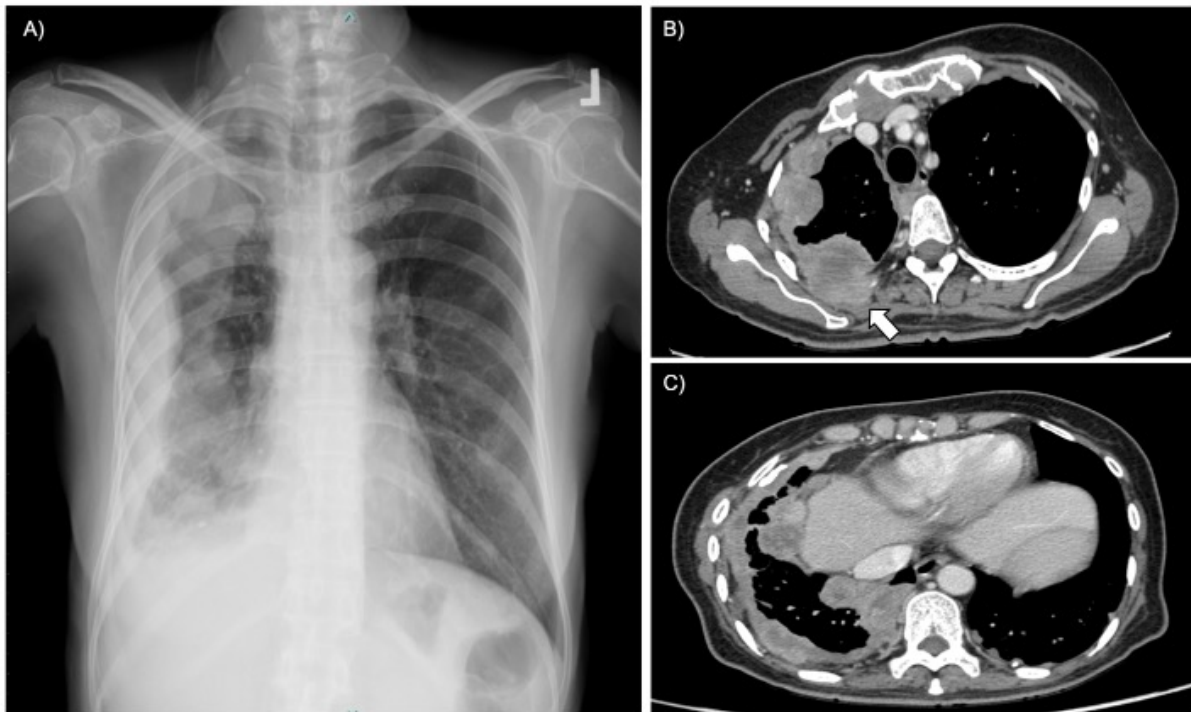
Initial chest imaging of the patient, A: Chest radiograph showing extensive lobulated pleural masses in the right hemithorax, B-C: Axial contrast-enhanced chest CT images at the upper and lower thoracic levels (mediastinal-window setting) demonstrating concentric nodular pleural thickening and lobulated pleural masses with heterogeneous enhancement, including extension to the posterior chest wall muscles (arrow in B).
